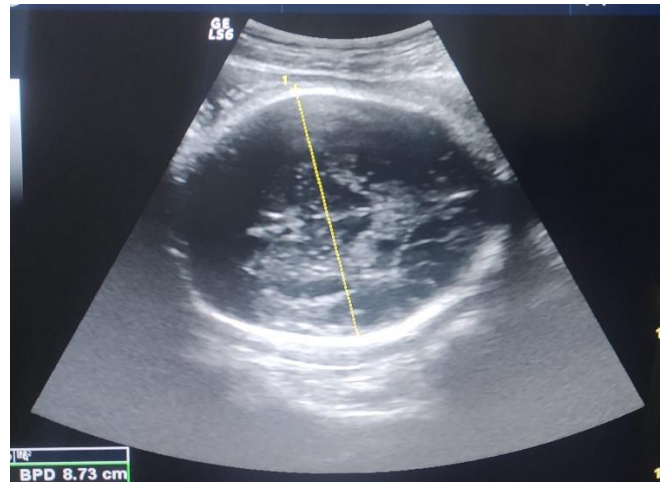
Sonographic measurement of biparietal diameter. (BPD)
